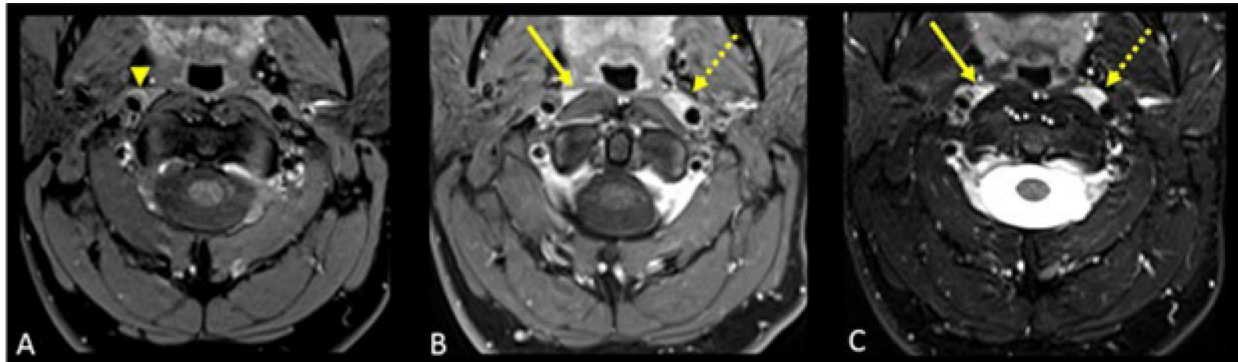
MRI of the neck. Axial T1-weighted fat-saturated image (A) shows crescentic T1 hyperintensity surrounding the lumen of the distal cervical segment of the right internal carotid artery (arrowhead), representing dissection. Axial postcontrast T1-weighted fat saturated (B) and T2-weighted fat saturated (C) images show a small right superior sympathetic ganglion (solid arrow) as compared to the left (dotted arrow).
